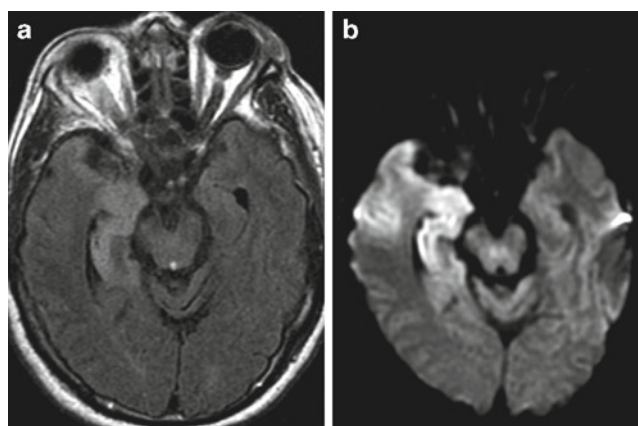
Herpes simplex encephalitis. (a) There is FLAIR hyperintensity with (b) restricted diffusion in the medial and anterior right temporal lobe. Note that there is overall increased lesion contrast on the DWI image (b) compared to the FLAIR image (a)
